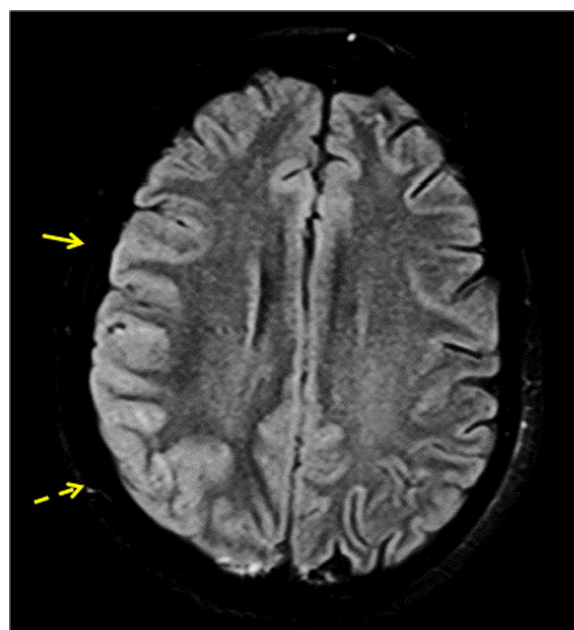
Magnetic resonance imaging shows cortical thickening and sulcal effacement involving right posterior frontal (arrow) and parietal lobes (dashed arrow) with high T2/FLAIR signal intensity
